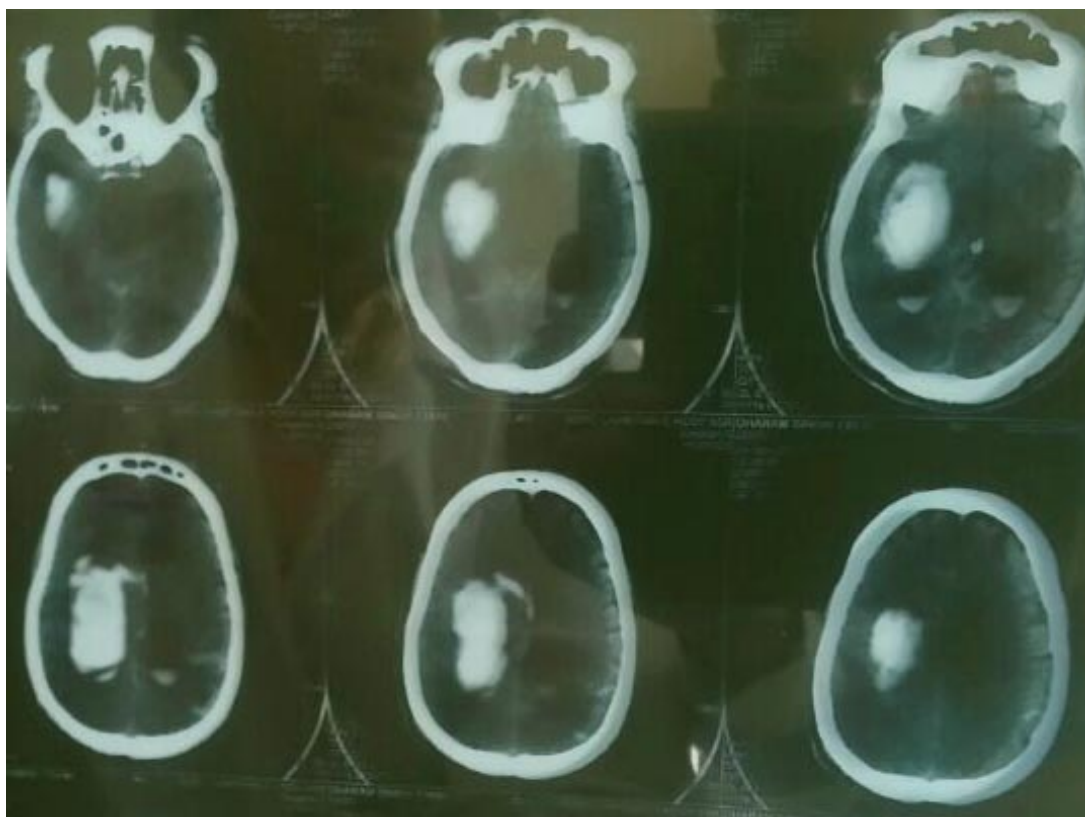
Mass lesion seen in temporal lobe on CT scan plate
